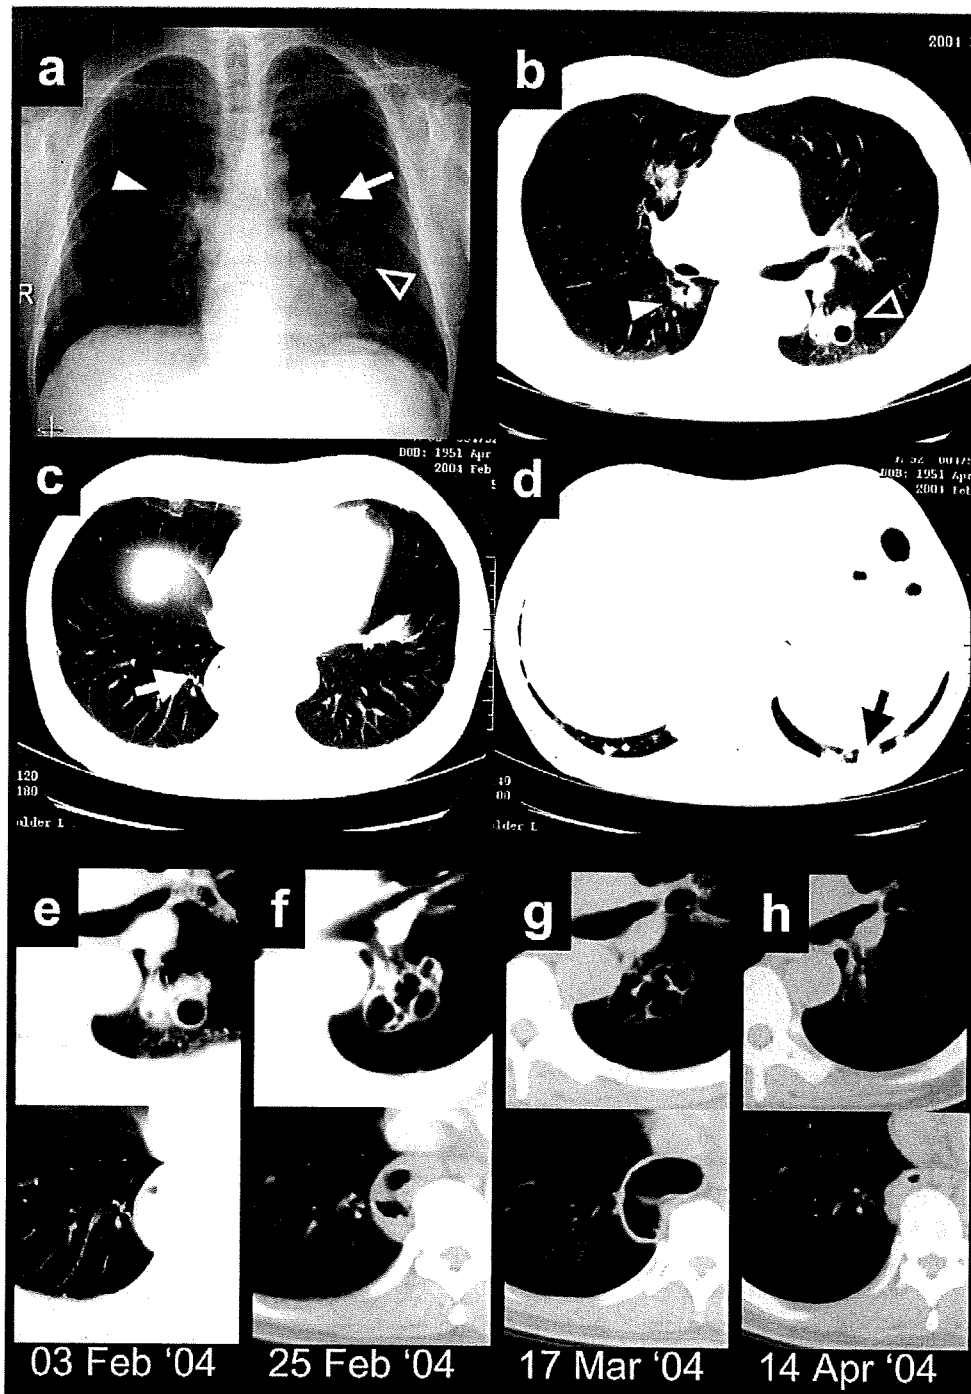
Radiological findings of PCP with cavitory lesions. (a) Chest X-ray on admission to our hospital demonstrating a cavitory lesion at left hilum (arrow) and consolidations at middle right (arrowhead) and lower left lung fields (blank arrowhead). (b–d) Chest CT scans recorded at a local hospital showed thick-walled cavitory nodules at left S6 (b, blank arrowhead), right S6 (b, solid arrowhead), right S10 (c, arrow) and left S10 (d, arrow). (e–h) Time-course analysis of chest CT scan showed spontaneous ballooning of cavities and their disappearance after completion of PCP treatment (upper panels; left S6, lower panels; right S10).
